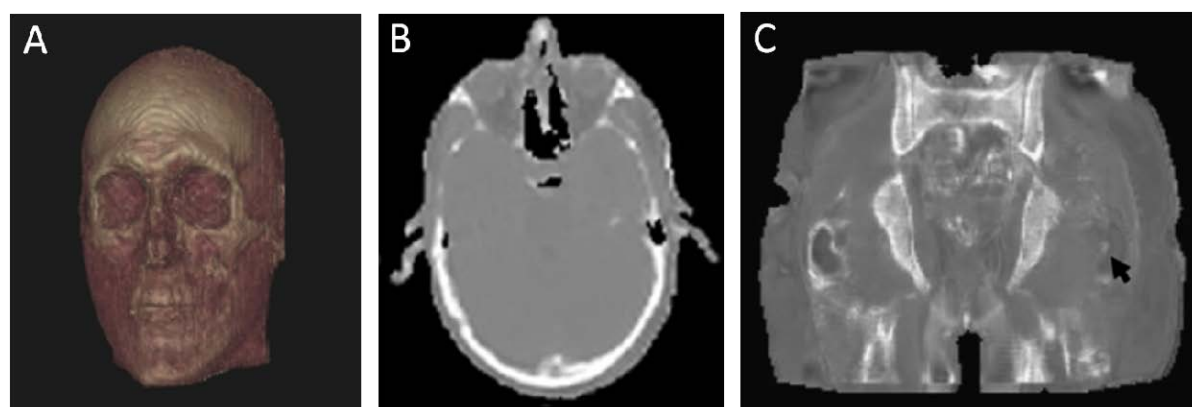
Adding bone to MR-based attenuation correction (AC) with UTE sequences. Three-dimensional rendering of MR-based bone information (A) of a patient. MR-based “pseudo-CT attenuation map (B) for attenuation correction of PET data that was acquired using a Dixon-VIBE and UTE sequence and pattern recognition information. Coronal view (C) of MR-predicted “pseudo-CT” data acquired in the pelvis of a volunteer using the Dixon-VIBE and UTE acquisition model.
